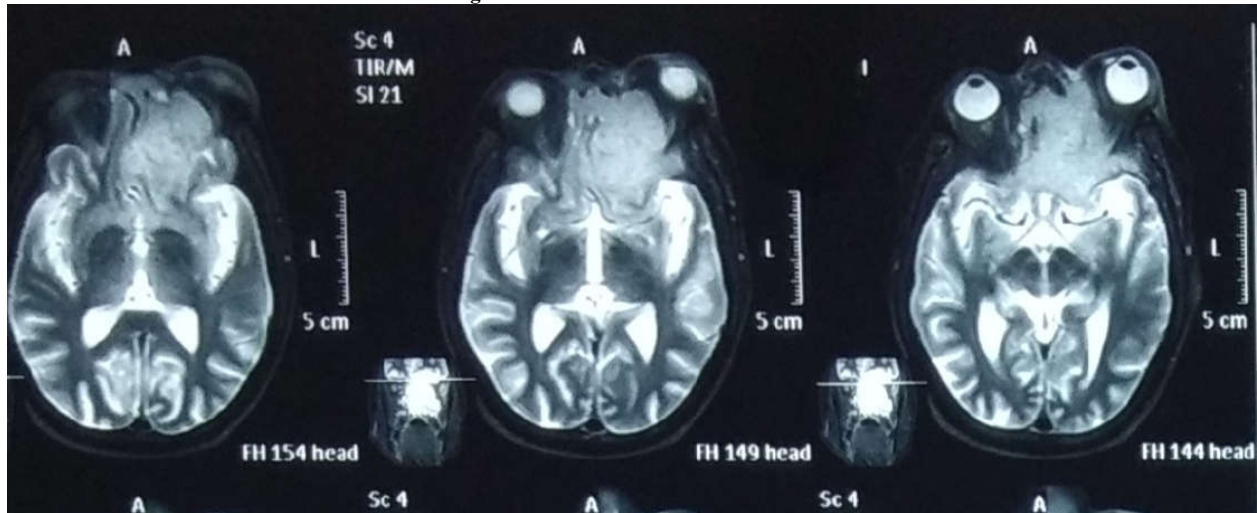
T2 MRI of the sinuses and brain
